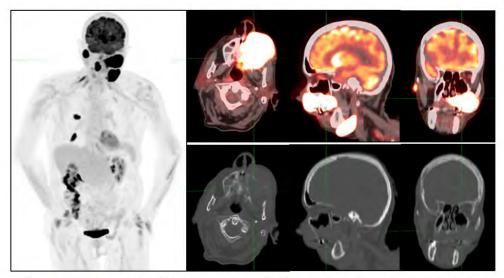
Left maxillary palatal high-grade lymphoma. Pre-treatment PET/CT revealed a large, hypermetabolic maxillary palatal lesion centered in the left hard palate, this lesion extended anterior-superiorly with erosive changes of the left maxilla sinus, with SUV max 24.0. Additionally, there was a hypermetabolic lesion at the right palatine tonsil with SUV max 24.0. There was an enlarged, hypermetabolic right intraparotid lymph node with SUV max 24.1, as well as a left level 1B conglomerate lymph node with SUV max 24.7. There were hypermetabolic lesions in the right lung, concerning for pulmonary involvement of lymphoma. Biopsy of left maxillary palatal mass showed high-grade lymphoma.
